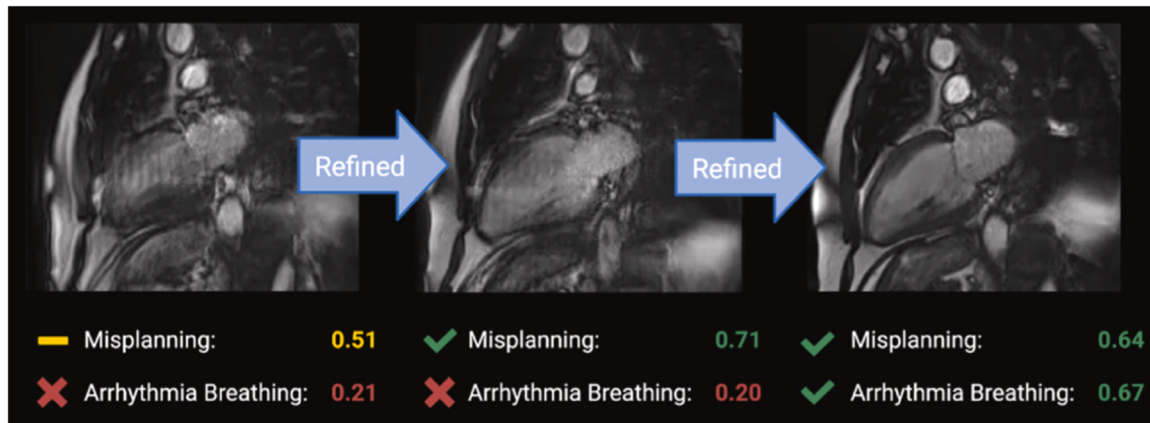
Example of an AI-based automated image quality control assessment. The three images show 2-chamber CMR cine views with varying AI-generated quality scores. The AI algorithm iteratively assesses image quality by analysing factors such as MR sequence planning and the presence of motion artefacts, providing radiographers with actionable feedback to improve image quality [18].
